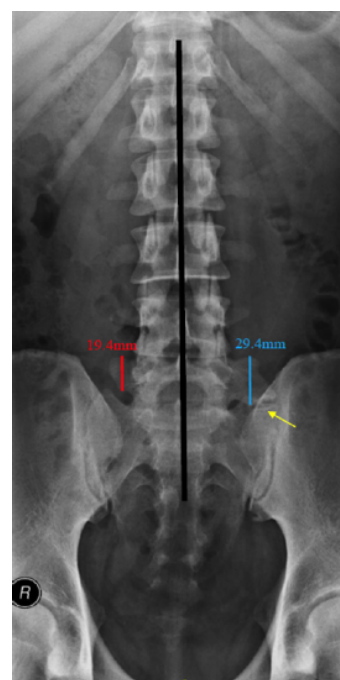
All spinous processes in the straight line and the pedicle distance to the spinous process on each side were similar, showing a true AP* view of the lumbosacral plain radiograph. L5 was set in a cephalad-to-caudal manner where the 12th rib was the marker and corresponded to T12. Type I LSTV was noted on the right transverse process of L5, measured 19.4 mm and dysplastic (red line). Type II LSTV was observed on the left side and measured 29.4 mm (blue line) with evidence of pseudo-arthrosis between the transverse process of L5 and sacrum (yellow arrow). *AP: Anteroposterior
